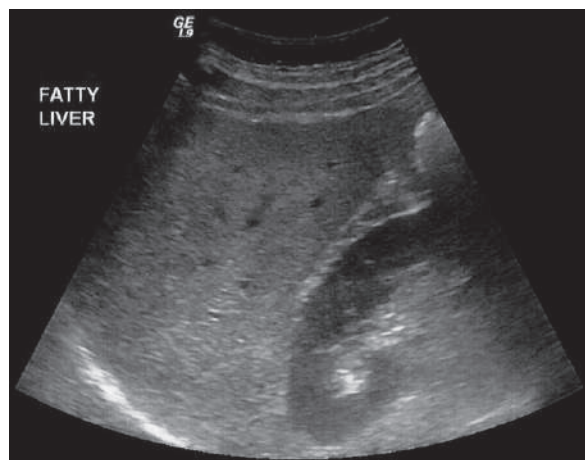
Transverse ultrasound image of the liver shows diffuse increase in liver echogenicity compared to the right renal cortex (liver steatosis)
